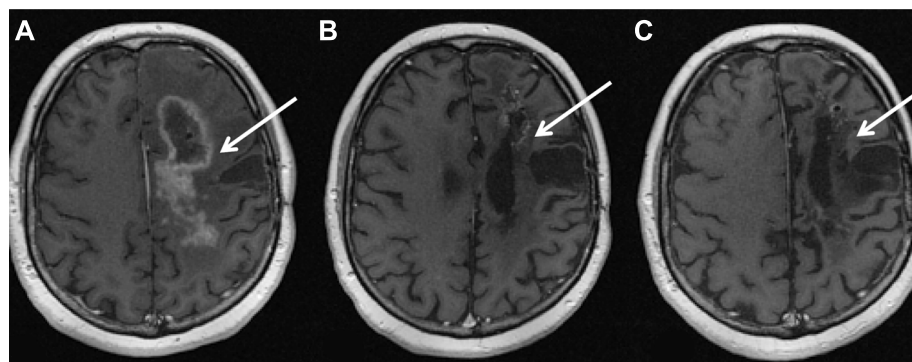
Magnetic resonance images of a patient with grade III glioma showing excellent response to locoregional treatment with 8 cycles of ^{213}Bi -Substance P analogue with a cumulative activity of 14.1 GBq (2 months after first therapy (A); 8 months after 8th therapy (B); 33 months after 8th therapy (C)).
